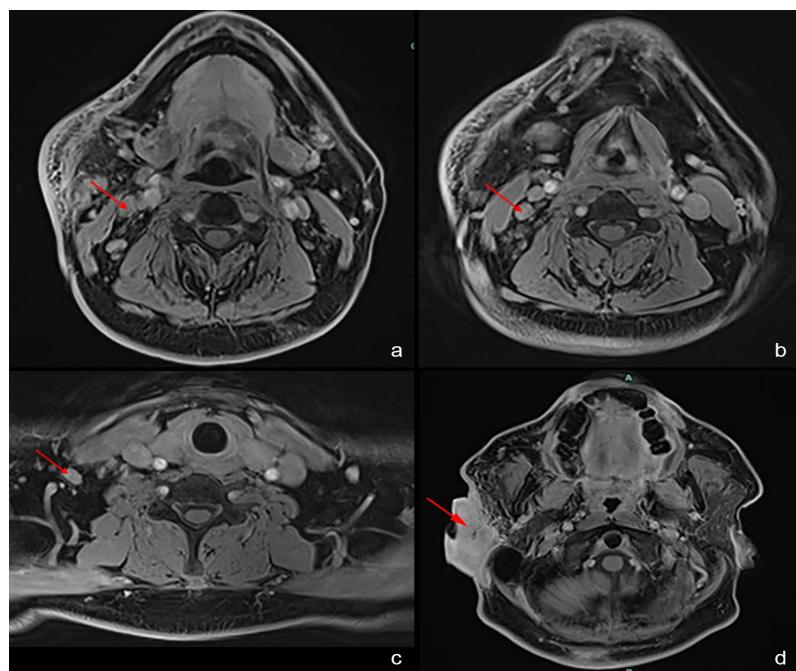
MRI images showed (a-c) enlarged and enhancing lymph nodes at levels 2, 3, and 4 of the right cervical neck regions; (d) lobulated soft tissue mass measuring 2.6 cm x 4.9 cm x 6.3 cm in the right pre- and postauricular space
